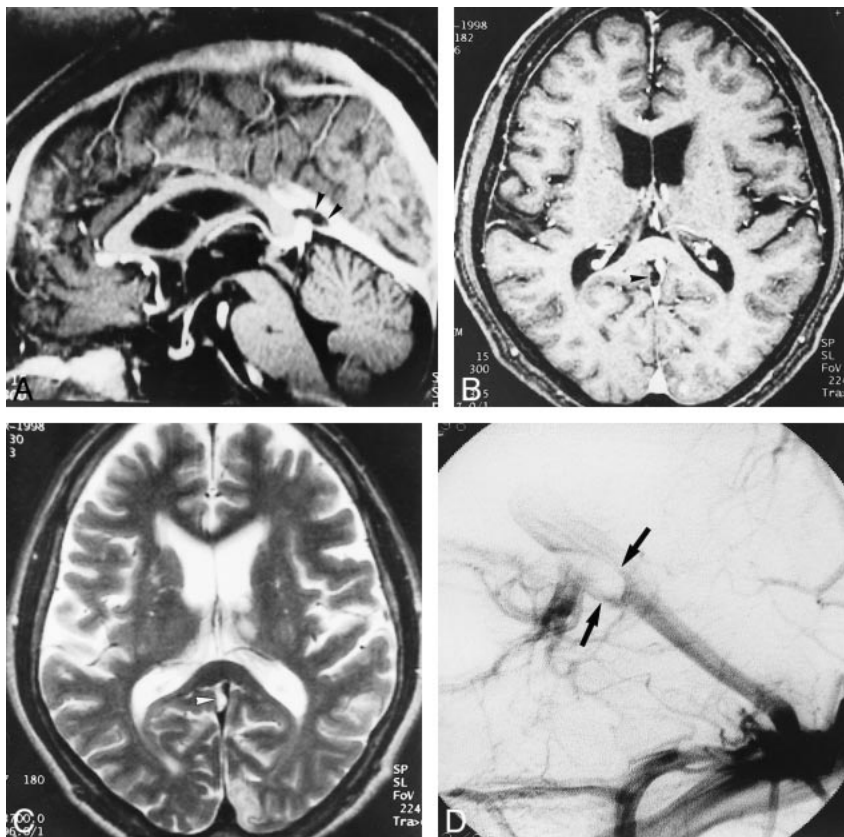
A–D, Large pacchionian granulation at the top of the straight sinus (arrowheads). Pacchionian granulation is hypointense on reconstructed sagittal and source axial images (A and B) of 3D contrast-enhanced MP-RAGE (13.5/7/1, TI = 300, flip angle = 15°) and hyperintense on T2-weighted image (C) (3700/96/1). DSA image (D) shows filling defect in corresponding region (and could be misdiagnosed as a sinus thrombus).
